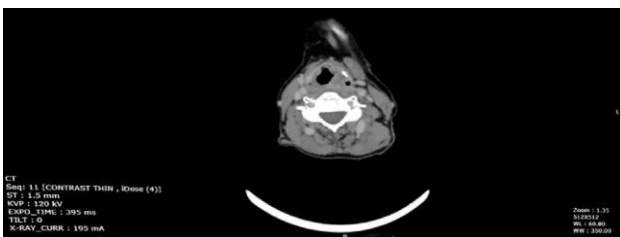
Contrast enhanced computed tomography neck showing left asymmetrical heterogeneously enhancing soft tissue thickening involving apex of left pyriform fossa and aryepiglottic fold partially obliterating left pyriform sinus.
